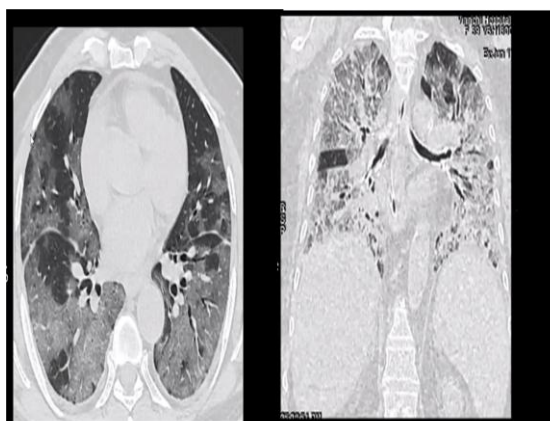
Axial and Coronal CT images of 46 year old co morbid patient showing the progression from Ground glass opacities to organized pneumonia
